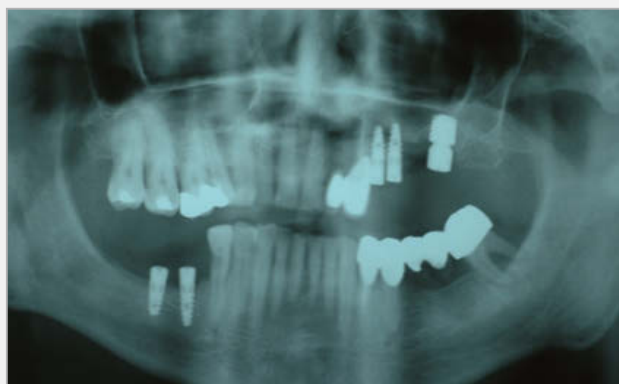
Case 2 - X-ray after uncover of the implant with healing screw in position.
